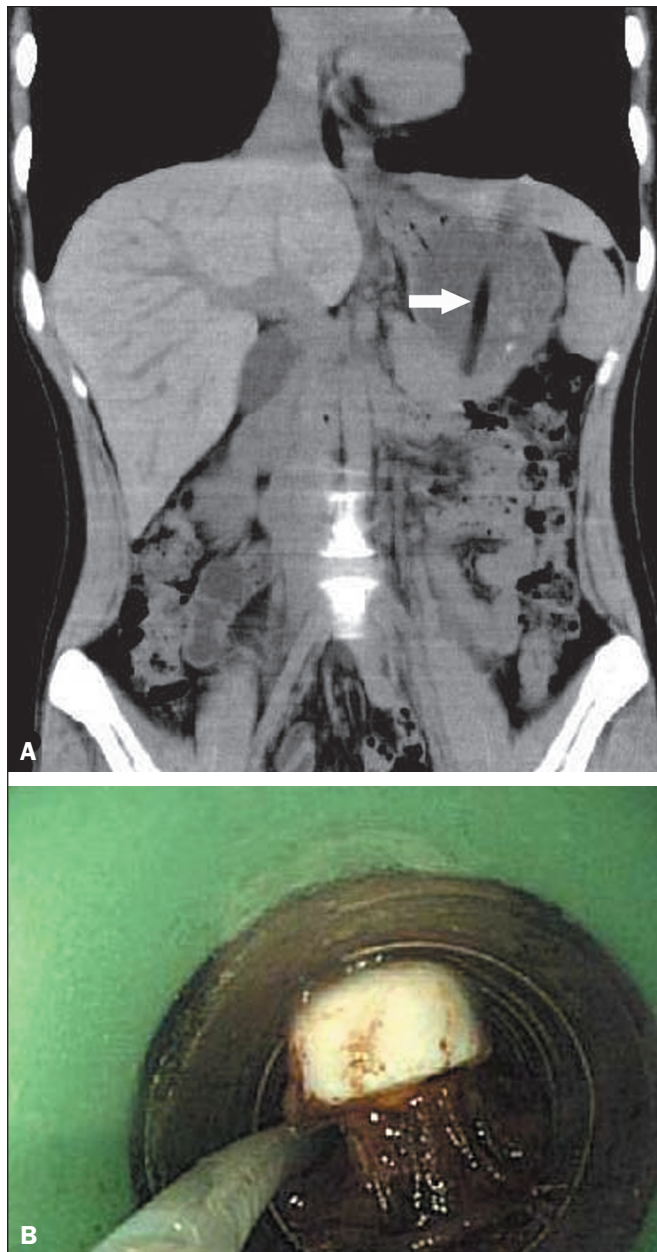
A 19-year-old woman who accidentally swallowed a toothbrush. A: Coronal reformatted CT image of the abdomen showing the toothbrush handle (arrow) lodged in the stomach. B: Photograph obtained during endoscopic removal of the item.
